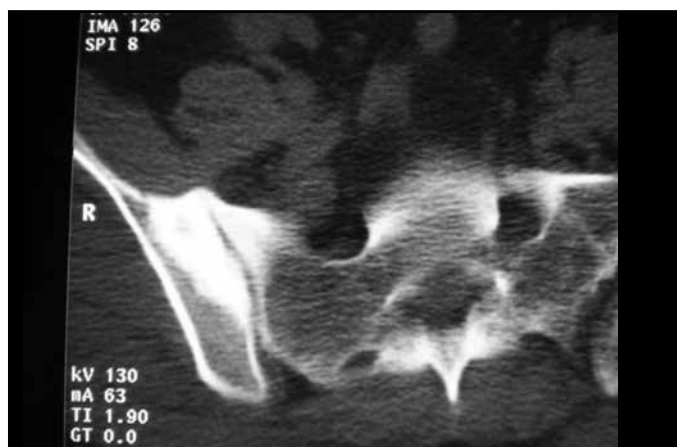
Case 2: computed tomography on the right iliac bone.
